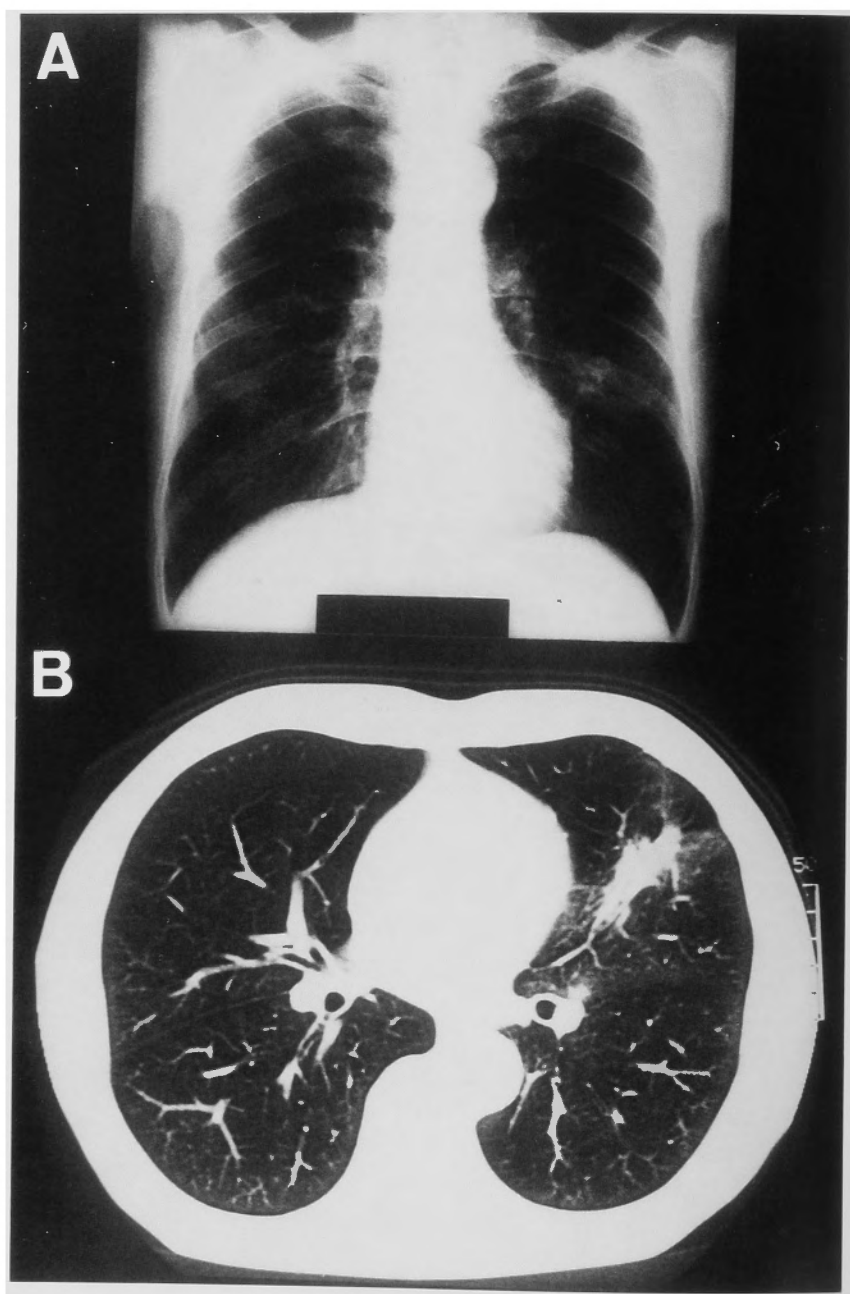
Chest X-ray and chest CT examination in case 2. In the left lower pulmonary field (S₅), a shadow of a nodular tumor 3 cm in diameter was observed.
